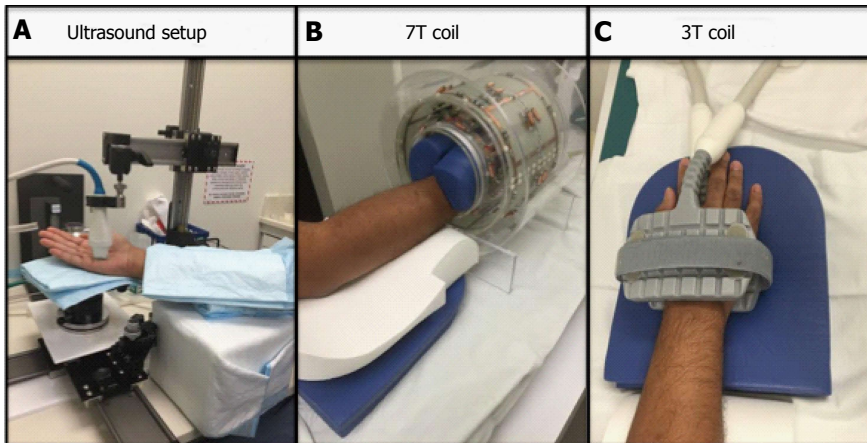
The figure shows the set up for the ultrasound (A), the 7T (B) and the 3T (1) respectively.
